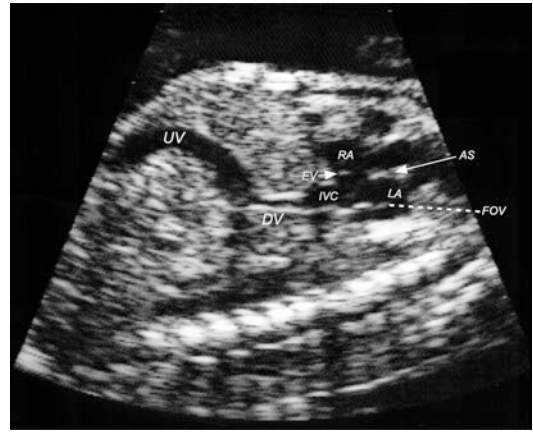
Ultrasound image of the fetal shunt ductus venosus (DV) at 30 weeks of gestation, connecting the intra-abdominal umbilical vein (UV) directly to the inferior vena cava (IVC) just before the latter penetrates the diaphragm to enter the heart. Note that in this sagittal section, the abdominal IVC is not visualized as it is slightly to the right in the fetus. Envisage that the blood from the DV flowing through the IVC is directed essentially behind the atrial septum (AS) to enter the left atrium (LA). Note also that the foramen ovale valve (FOV) and the shorter Eustachian valve (EV) operate as an extension of the IVC, fencing the ascending blood column from the LA and right atrium (RA) until it hits the edge of the AS, called the crista dividens, and is either distributed to the LA via the channel between the AS and FOV or to the RA. A corresponding sagittal section to the right would have exposed the abdominal IVC in a more anterior direction connecting to the RA
